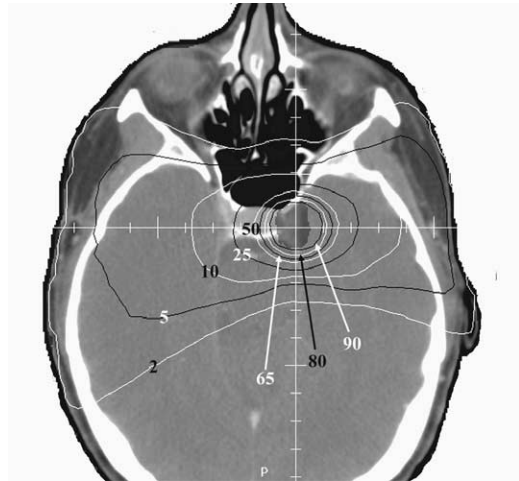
Transverse CT image with superimposed isodose lines of 2%, 5%, 10%, 25%, 50%, 65%, 80%, and 90% for the treatment of a residual pituitary adenoma in the left cavernous sinus. The irregularly shaped lesion had a volume of 2.3 cm³, with dimensions of 13.0 mm (X) × 17 mm (Y) × 22 mm (Z). The treatment plan was developed with seven evenly spaced arcs. The lesion was fully covered with the 90% isodose line.
